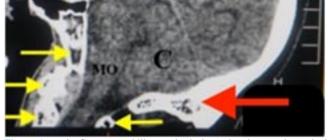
Brain CT scan (midline sagittal view) showing craniocervical junction and posterior cranial fossa.
